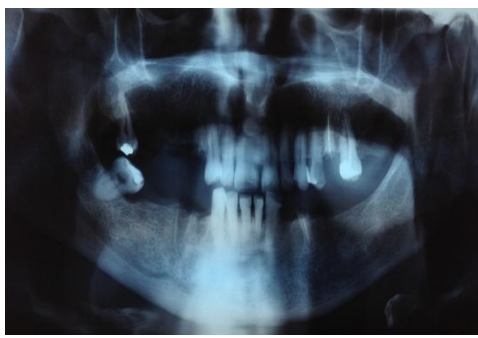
Panoramic radiography showing the absence of osseous healing after 3 months of extraction at the site of 44 and 45.
